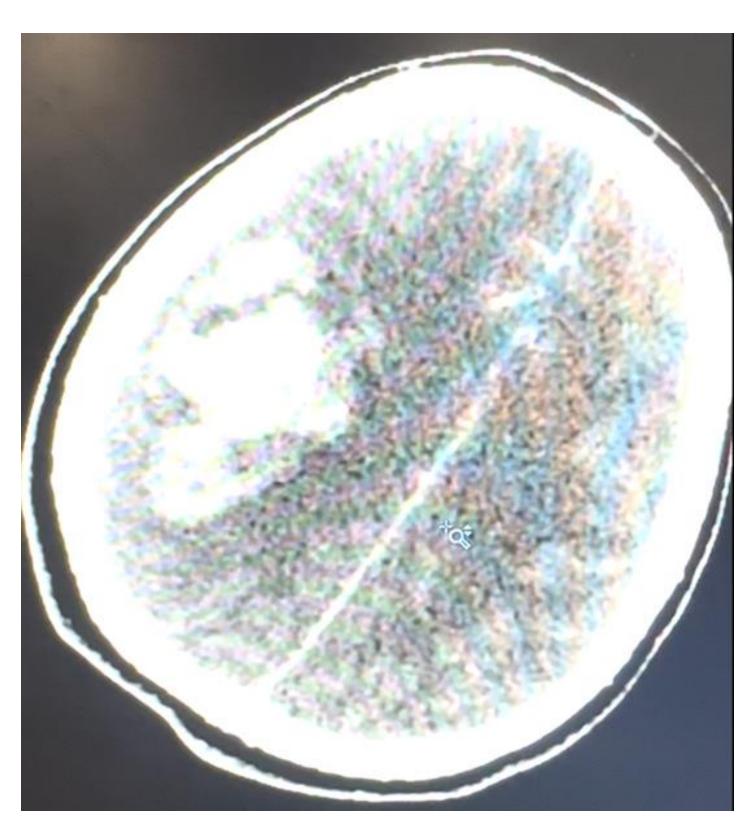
Repeat CT Head two hours later after change of mental status
